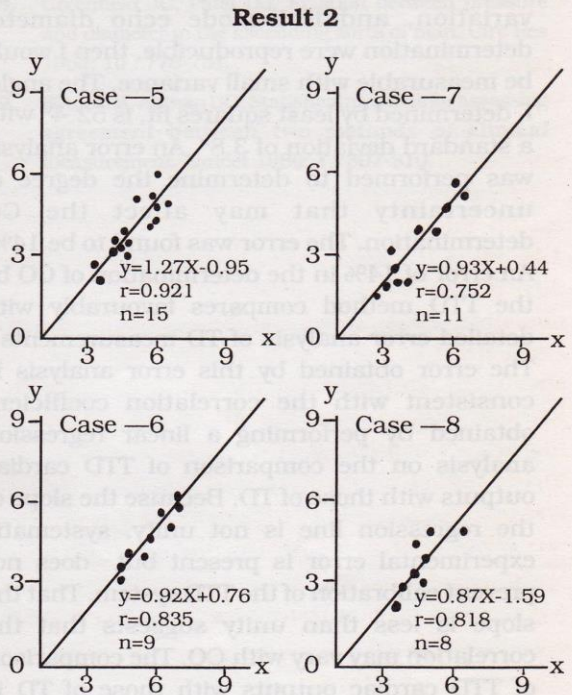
Scatter plot of Transtracheal Doppler cardiac output (y-axis) versus Thermodilution cardiac output (x-axis)
